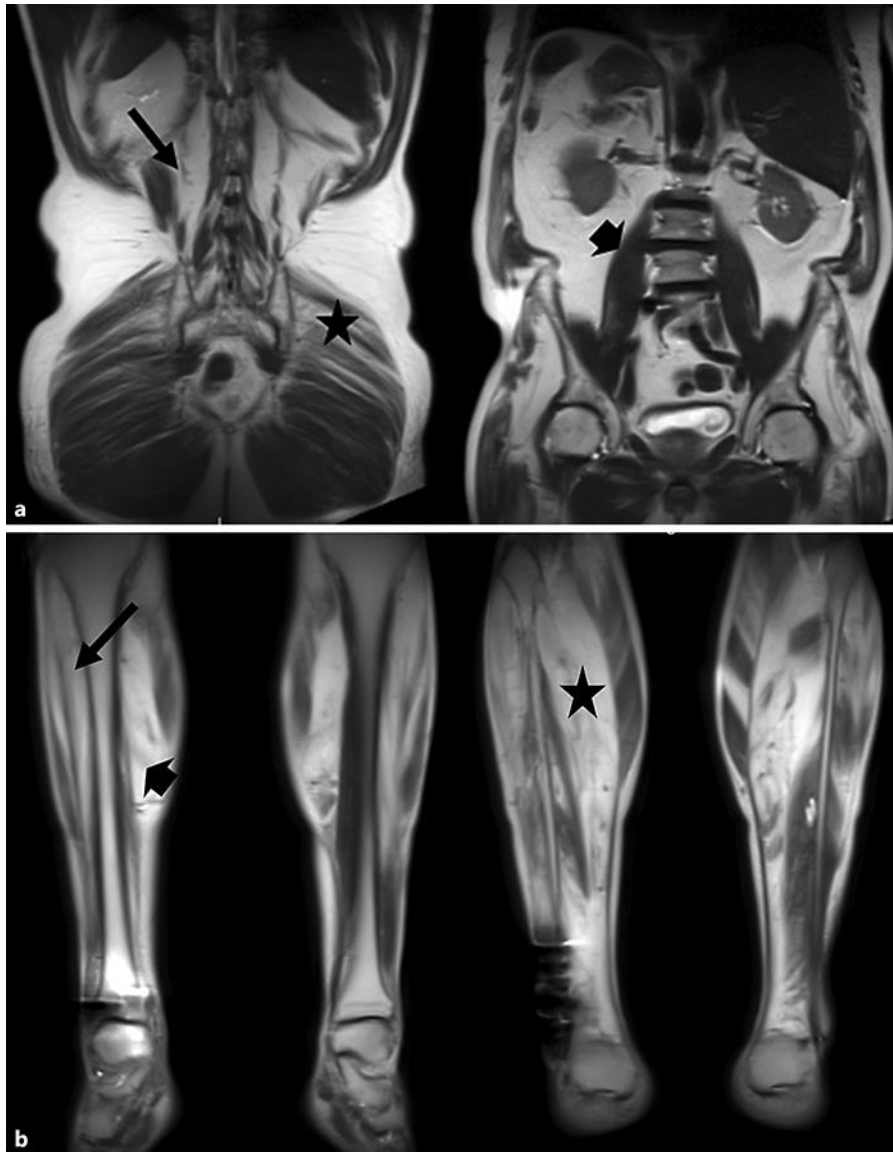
Representative whole-body coronal MRI sections (TE: 87, TR: 2,000, FA: 150). a At the level of the trunk, there is marked fatty replacement of lumbar paraspinal muscles (long black arrow) whereas the psoas muscles are relatively spared (arrowhead). There is also moderate fatty streaking of the gluteus medius muscles (star), more prominently than in the gluteus maximus. b At two different anteroposterior levels of the calf, there is marked fatty replacement of the tibialis anterior (long black arrow), medial gastrocnemius (arrowhead), and soleus muscles (star).
